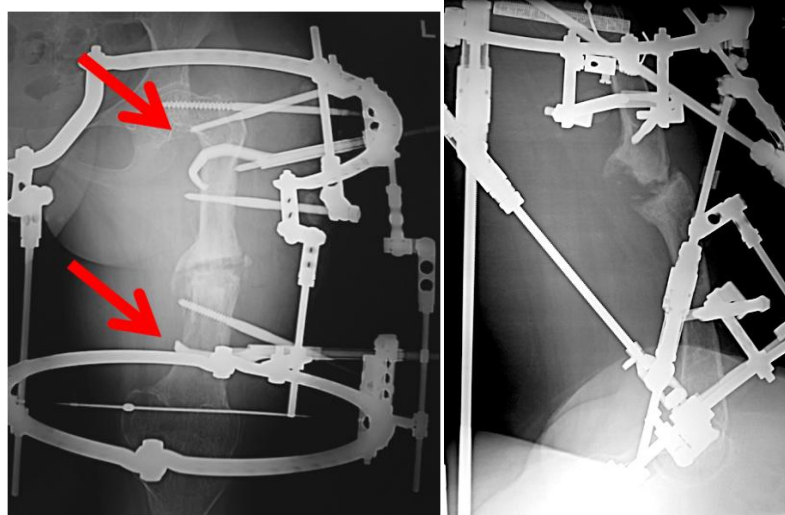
Photos and x-ray films of patient S., 22 y.o., with complex deformities of the femurs and lower legs: a – preoperative planning; b – intraoperative photo: two-level osteotomy of the femur with simultaneous correction of the deformities and intraoperative fixation by ExFix frame on the base of 2 SUV-clamp s (pointed by arrows) and further BIOS; c – after the surgery
